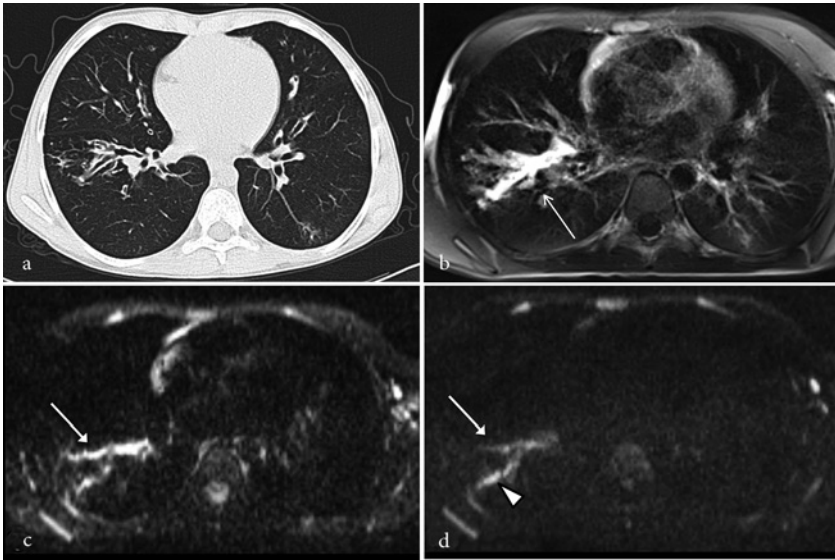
(a) End-inspiratory axial CT, (b) free-breathing PD-weighted axial BLADE image, (c) Diffusion Weighted Imaging (DWI) free breathing ($b=0 \text{ s/mm}^2$) and (d) DWI ($b=600 \text{ s/mm}^2$). A large bronchiectasis filled with mucus can be appreciated in the right lower lobe (arrow in b). Note heterogeneous DWI signal decay in highest b-value of the mucus-filled bronchiectasis (arrow in c and d), although it persists in the dorsal branch due to persistent restricted diffusion (arrowhead in d).
